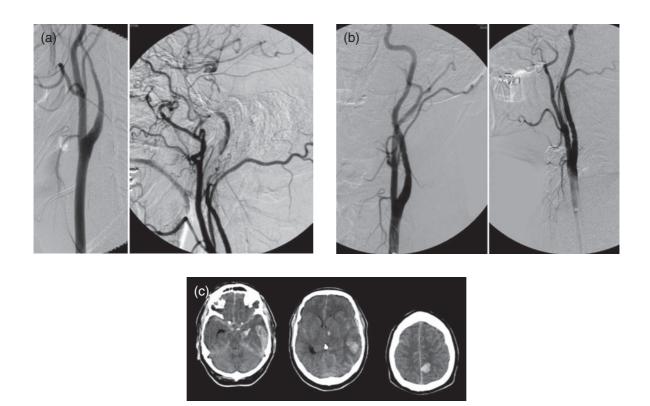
(a) Angiogram demonstrating the extent of the flow-limiting dissection. *Left,* lower cervical (AP view); *right,* higher cervical (lateral view). (b) Immediately after the deployment of overlapping Xpert[™] stents (Abbott Vascular, Inc, Redwood City, CA). *Left,* AP view; *right,* lateral view. (c) CT images demonstrating non-synchronous, non-confluent ICHs. *Left,* left temporal ICH and subarachnoid hemorrhage; *middle,* left temporal and left basal ganglia hemorrhages; *right,* left parietal ICH.
